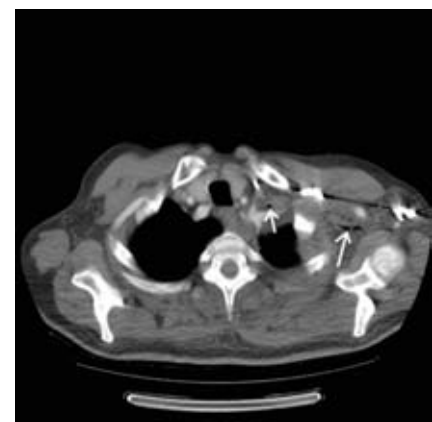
Computed tomography scan of thorax, showing loculations of air in the tissue of the mediastinum (white arrows) in patient #1.
